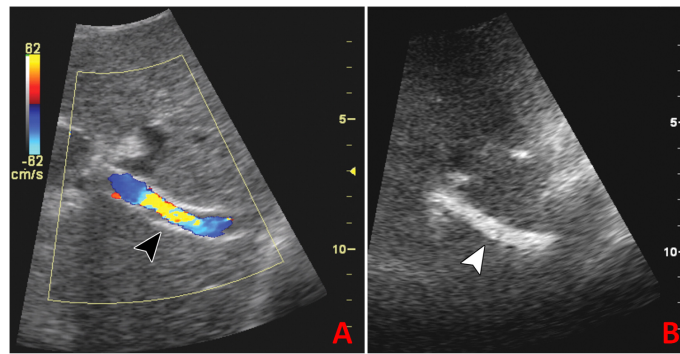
Example of Doppler ultrasound for vessel visualization in liver: (A) Overlay of speed map calculated in region of interest surrounded in yellow show stenosis on the arrow (turbulences produce blood flow in several directions which are shown in colorful area). (B) As comparison the same slice is shown only in B-mode ultrasound, where vessel can be seen, but functional behavior is not visible. Image from [353] and reproduced with permission of the American Roentgen Ray Society.
